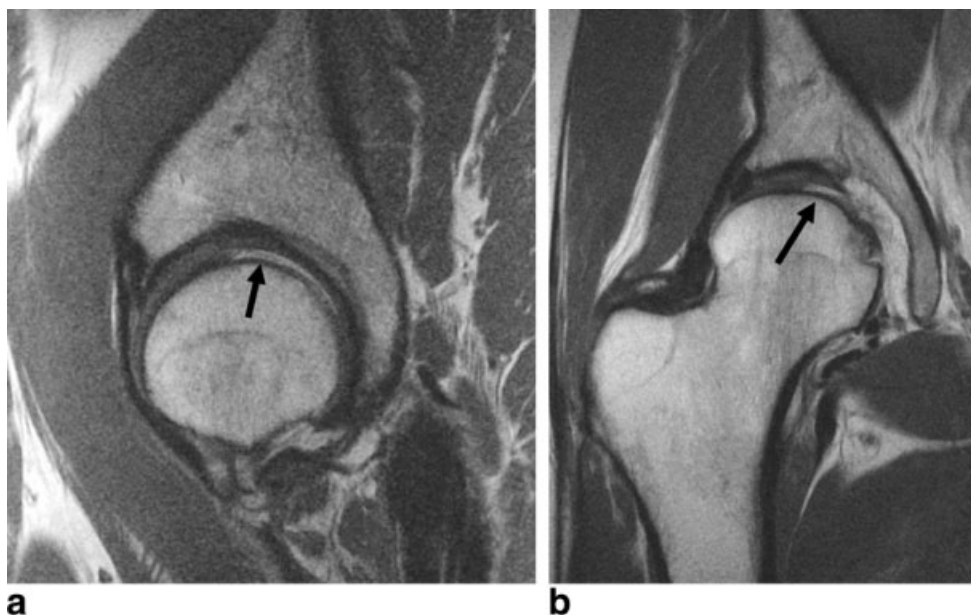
A,B: Sagittal (A) and coronal (B) MR images of a 53-year-old woman with preserved joint space on radiographs demonstrate active cartilage delamination (arrow on A) with large flap formation over the femoral head and an adjacent defect (arrow on B).
